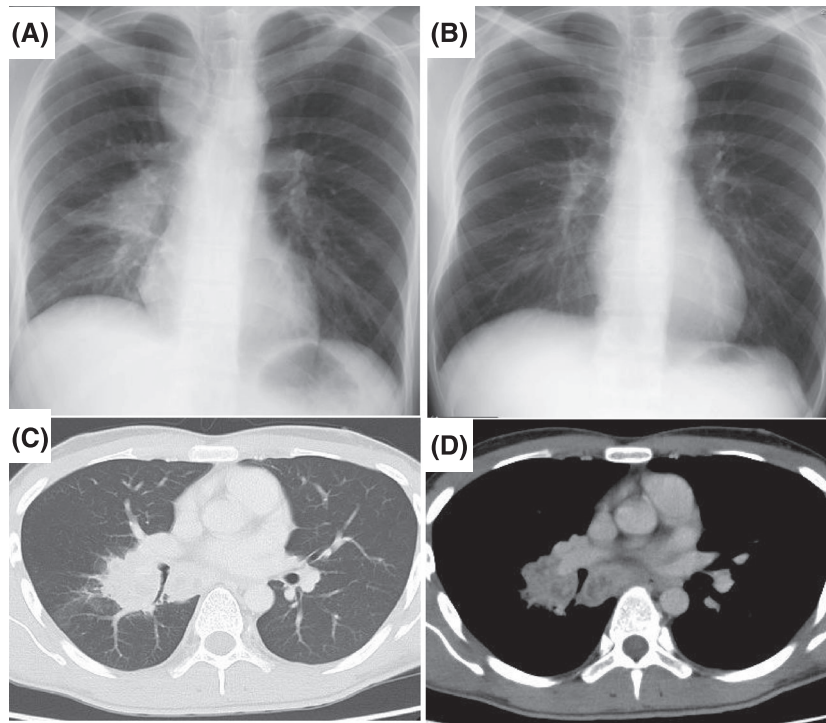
(A, C, D) A chest X-ray and computed tomography showed mediastinal and hilar lymphadenopathy with focal necrosis and partial atelectasis of the right lung. (B) The follow-up chest X-Ray three months after treatment initiation demonstrated a significant reduction in lymphadenopathy and disappearance of atelectasis.
